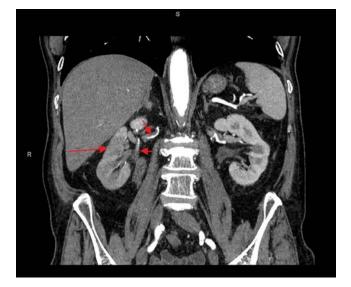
Computed tomography of the patient's abdomen at diagnosis, showing thickening of the walls of right renal artery branches (short arrows) and ischemia of right renal parenchyma (long arrow).
